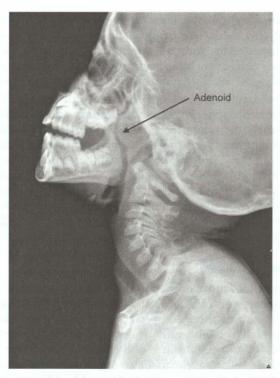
Lateral radiograph of the neck showing adenoid hypertrophy occluding the nasopharyngeal airway in a 6-yr-old boy (Courtesy: Textbook of ENT, Hazarika)
